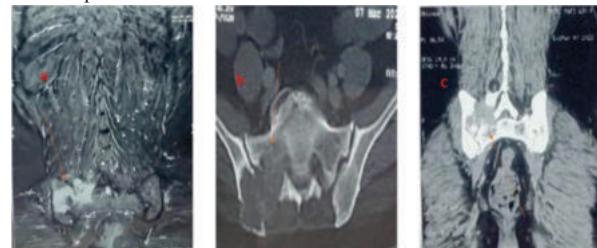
[A] Coronal MRI of sacro-iliac region showing expansive T2-hyperintense lesion involving right sacro-iliac joint and adjacent sacrum and ilium. [B] Axial CT of sacro-iliac joint showing expansive lytic lesion involving right sacro-iliac joint and adjacent sacrum and ilium. [C] Coronal reformed CECT of sacro-iliac joint showing expansive enhancing soft tissue attenuation lytic lesion involving right sacro-iliac joint and adjacent to sacrum and ilium.
